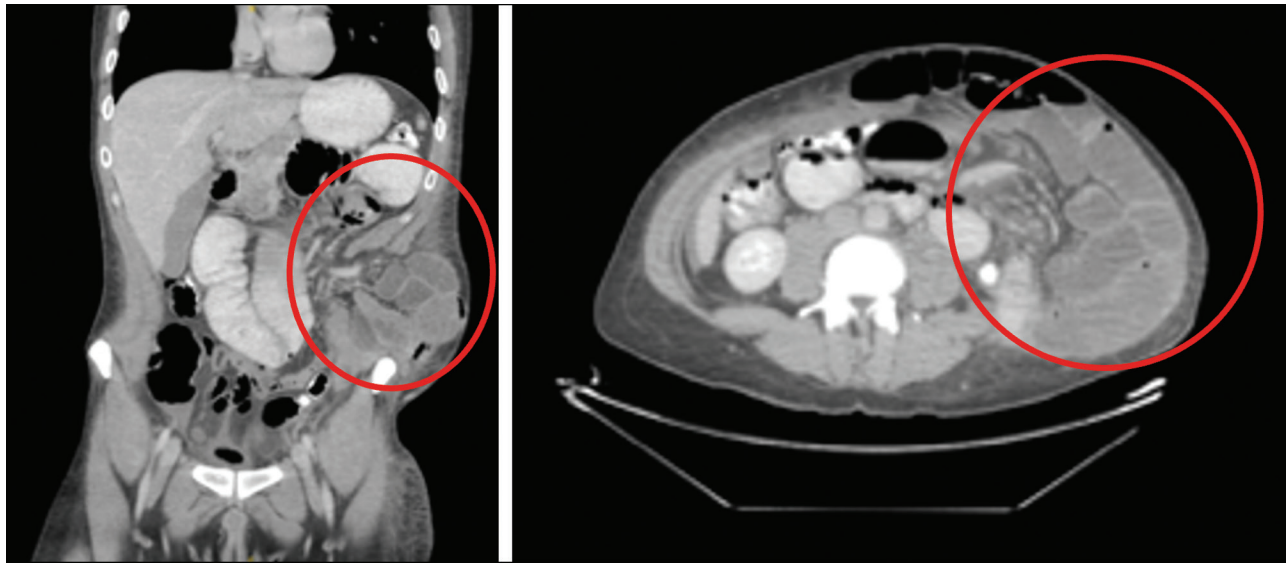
Pre-operative CT with oral contrast (partial SBO): Large left-sided abdominal wall defect 6 cm long containing small bowel loops dilated up to 3.3 cm in the transitional zone at the hernial neck and causing partial small bowel obstruction
